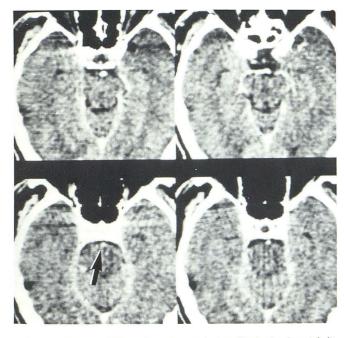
Case 10. Midbasilar artery occlusion. Contrast-enhanced dynamic CT scans. Attenuation values of basilar artery: *upper right*, 92 H; *upper left*, 96 H; *lower right*, 78 H; *lower left*, 45 H. Occlusion in scan at lower left (arrow).
